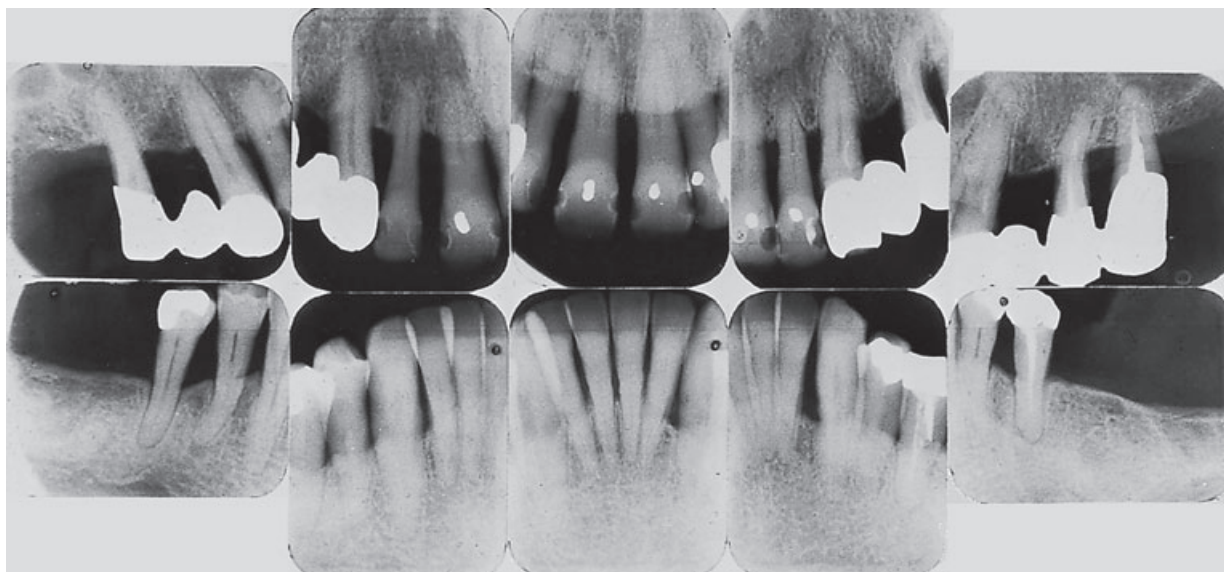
Case A. Radiographs obtained 10 years after periodontal therapy and installation of two unilateral bridges in the maxilla.
